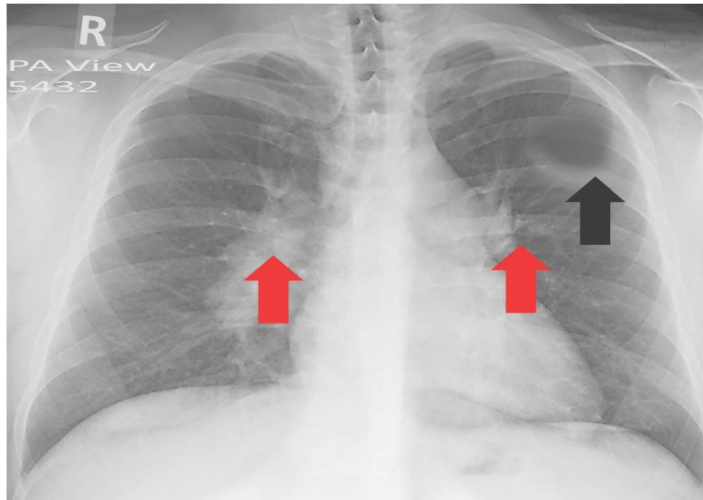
Chest X-ray demonstrating mediastinal and bilateral hilar lymphadenopathy with cavitary lesion in left upper lobe.
